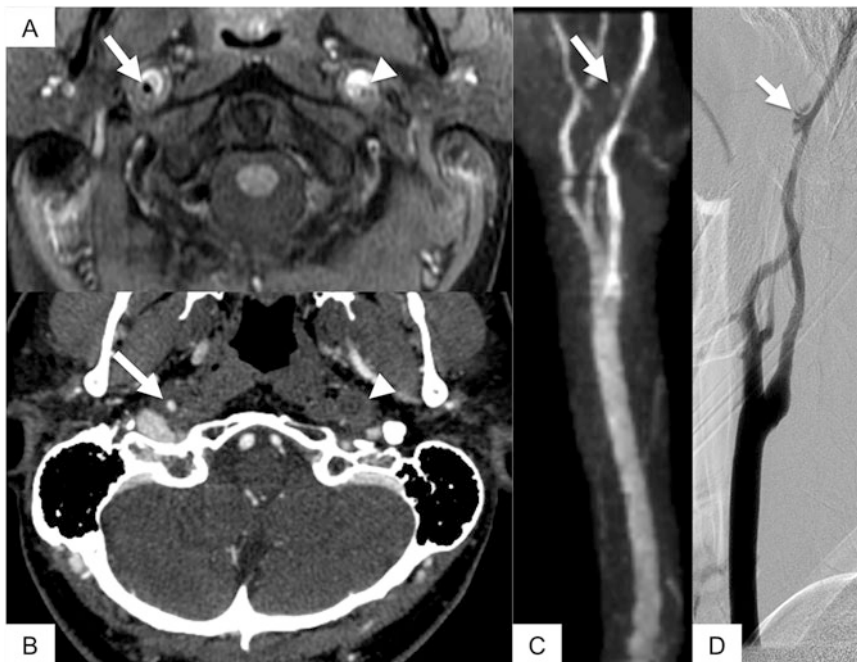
Bilateral carotid artery dissections. An 18-year-old presents with bilateral carotid artery dissections. MRI (a) and CTA (b) demonstrate occlusion of the left internal carotid artery (ICA) demonstrated by lack of the normal intraluminal flow void on the MRI and lack of intraluminal contrast on the CTA (arrowheads). The right ICA demonstrates narrowing with mural thrombus with a small central flow void on MRI (arrow, a), corresponding
